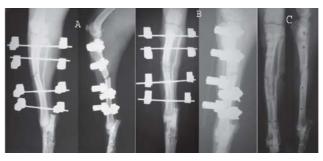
Radiographic evaluation. (A) Immediate post-operative, (B) 5 weeks post-operation and (C) healed fracture 7 weeks post-operation.
